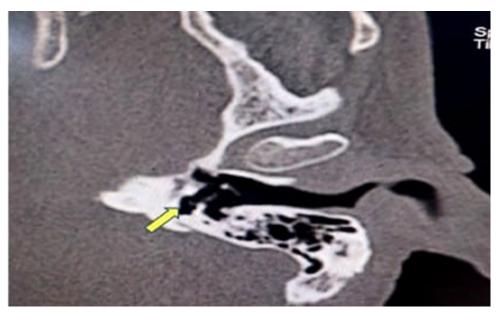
Inframillimetric CT image of the temporal bone in axial section showing the luxation of the stapes into the vestibule (Yellow arrow).
